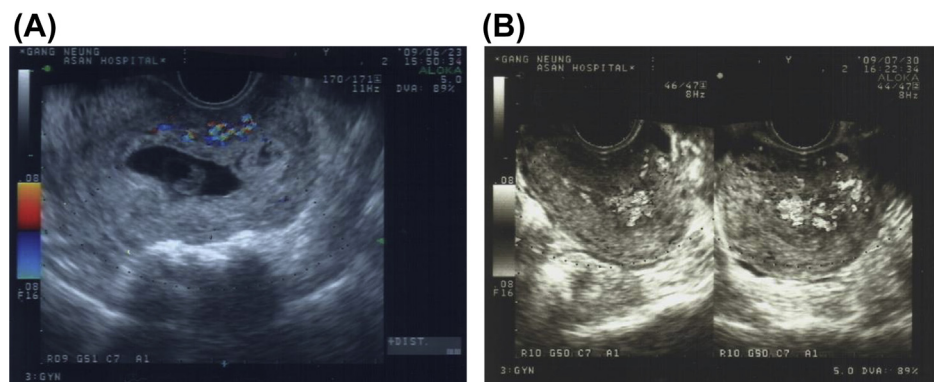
Color Doppler imaging of an arteriovenous malformation-like vascular lesion in a uterus with a missed abortion. A sagittal transvaginal color Doppler image of the uterus reveals (A) a tangle of vessels with multidirectional high-velocity flow producing a color mosaic pattern and (B) persistent vascular lesion of the uterus after dilation and curettage. In this case, massive vaginal hemorrhage during dilatation and curettage was expected, but vaginal bleeding was minimal. Thereafter, additional treatment was not required.
